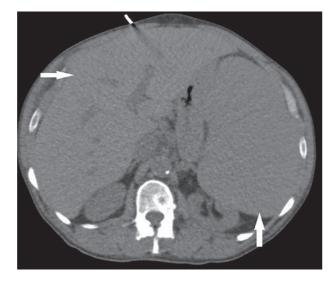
Computed tomography 1 month prior to admission; there is evidence of hepatosplenomegaly (white arrow).
